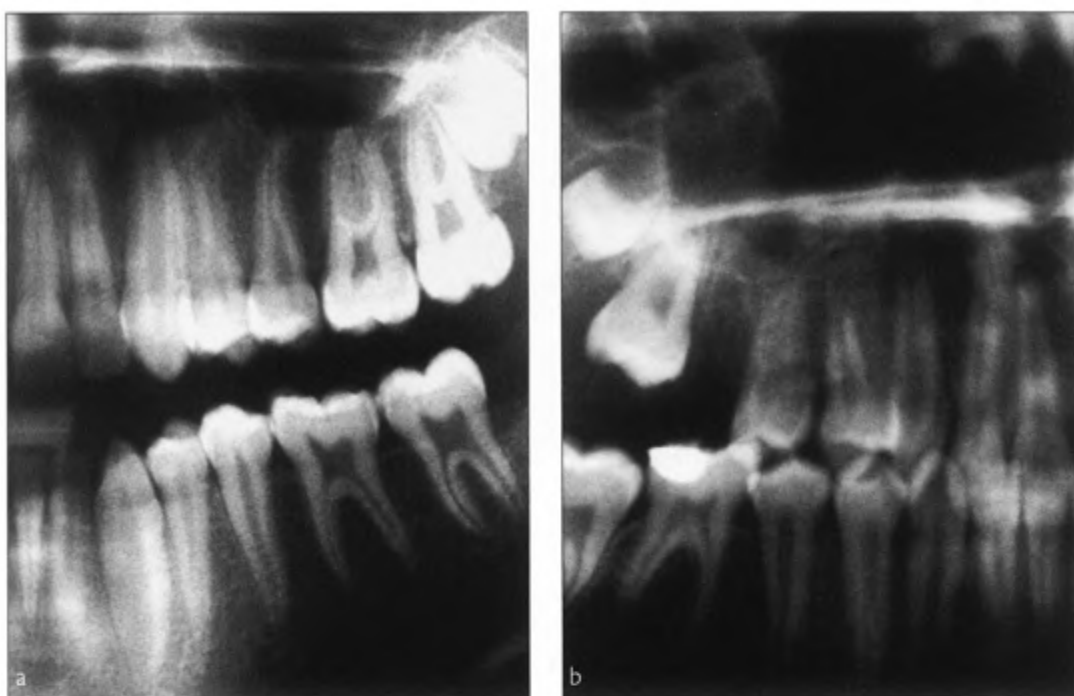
5b Panoramic radiograph indicates well-structured compact bone and simple maxillary sinus.
